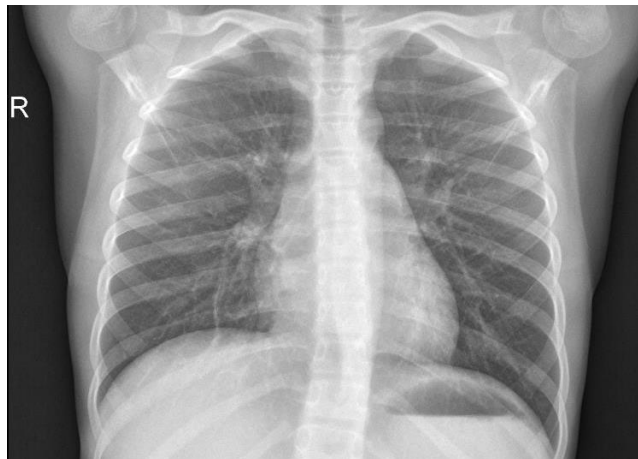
Chest X-ray image of a healthy person shown in Figure 1b.
